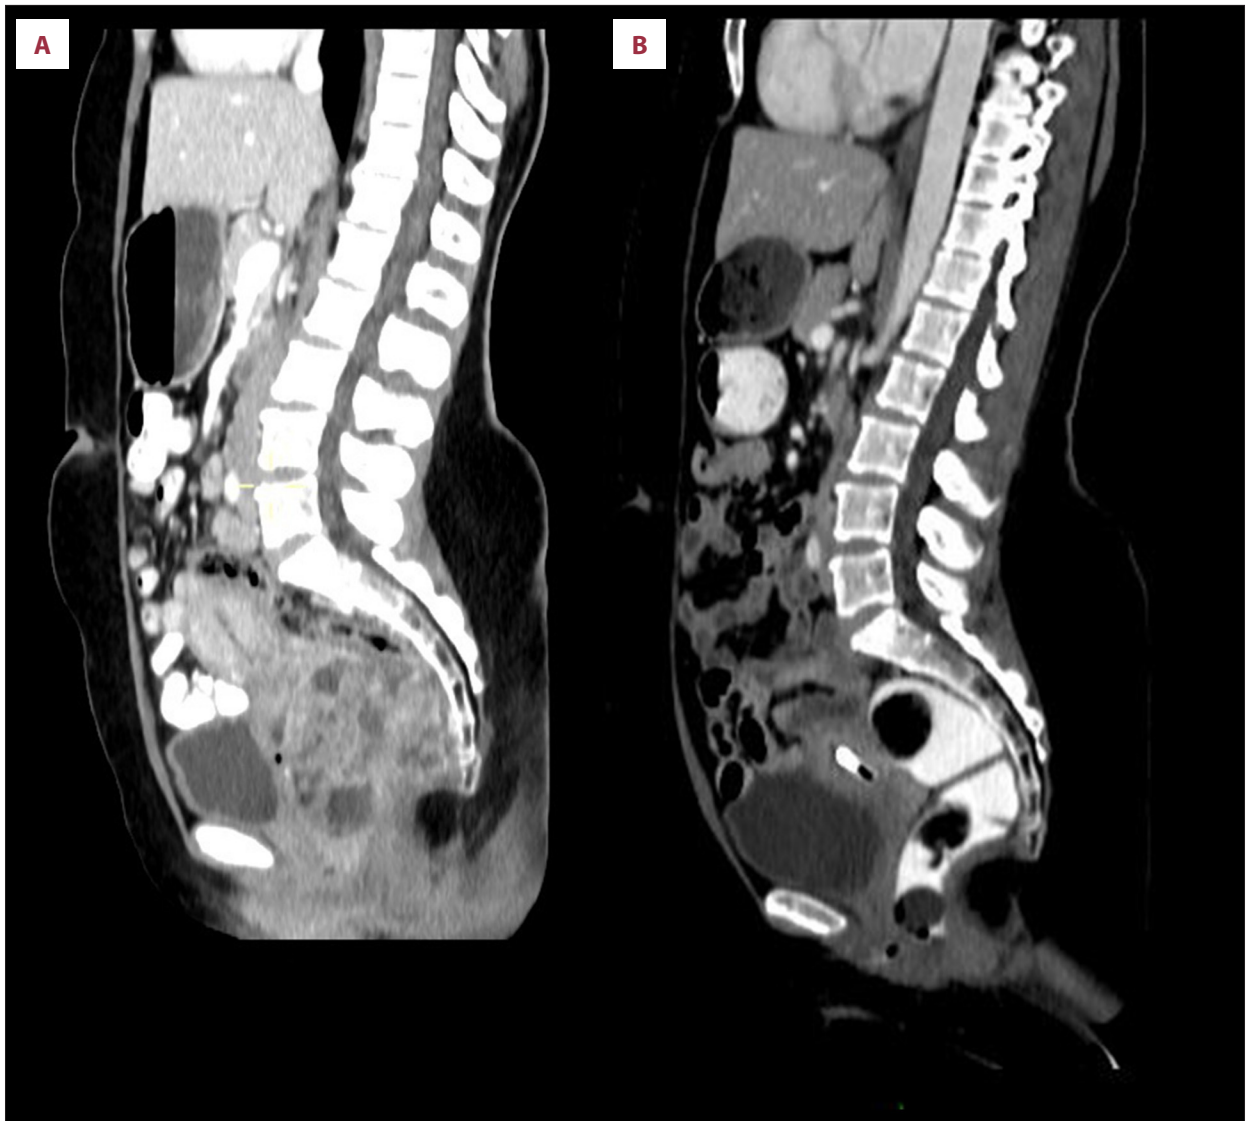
Computed tomography (CT) imaging in the sagittal plane. (A) (left) Computed tomography (CT) imaging before neo-adjuvant therapy. (B) (right). Computed tomography (CT) imaging in the sagittal plane following neo-adjuvant therapy.
